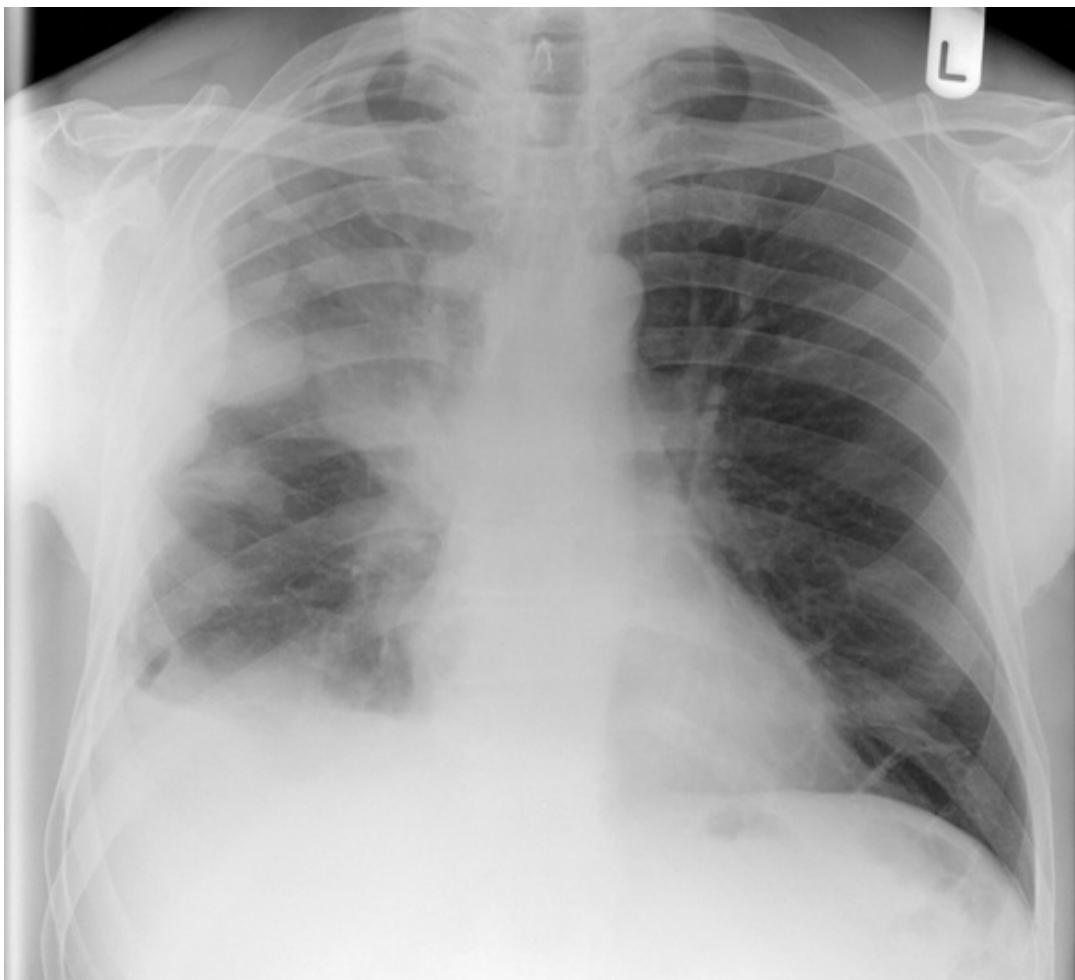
A CXR of a 68-year-old man with a history of asbestos exposure. He presented with right lateral chest wall pains. The CXR demonstrates lobulated pleural thickening around the upper, mid and basal right lung, with further pleural thickening evident next to the right side of the mediastinum. CT of a mesothelioma in a different patient is shown in [Figure 4.22](#).
